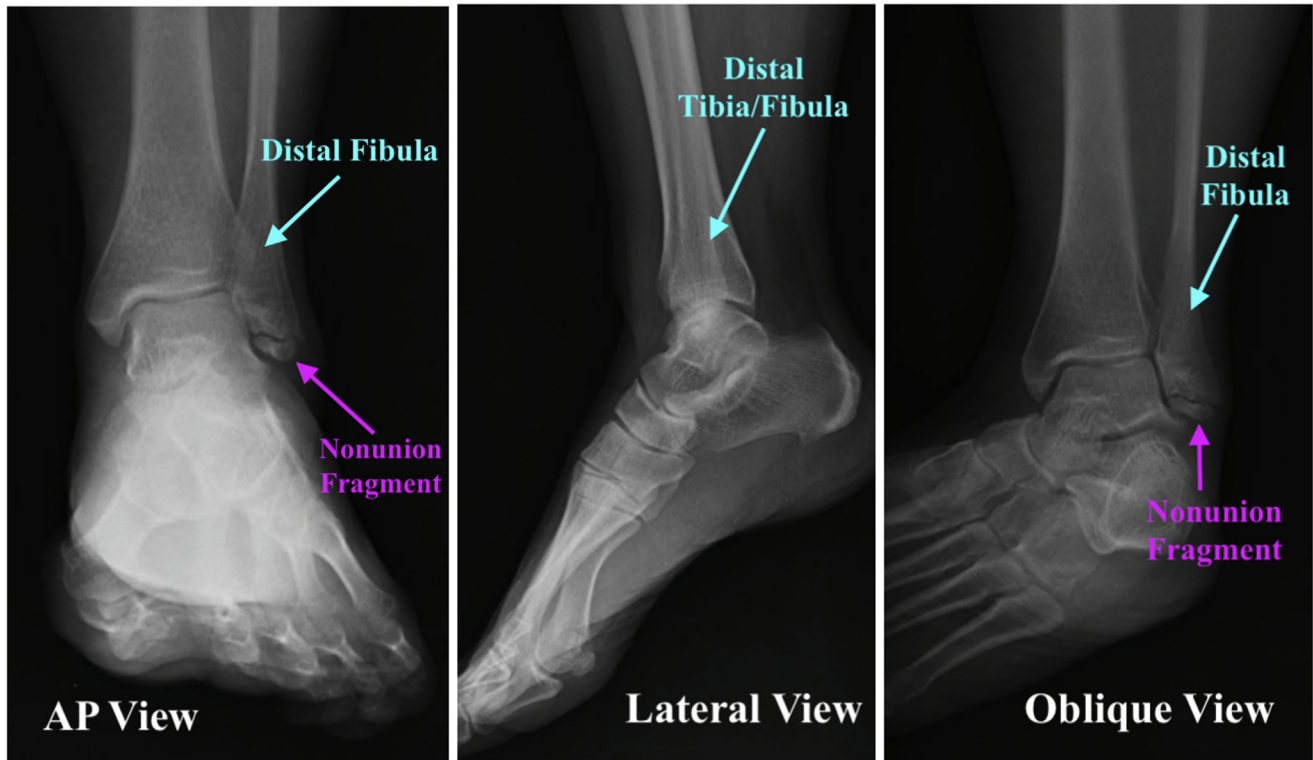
Preoperative radiograph images of the left ankle in the anterior-posterior (AP), lateral, and oblique views. In the AP and oblique view, a bone fragment is noted on the distal end of the fibula with no callus formation around the fragment. No osseous abnormality is noted on the lateral view. These radiograph images are significant indications for a nonunion of the distal fibula, with no evidence of healing.
